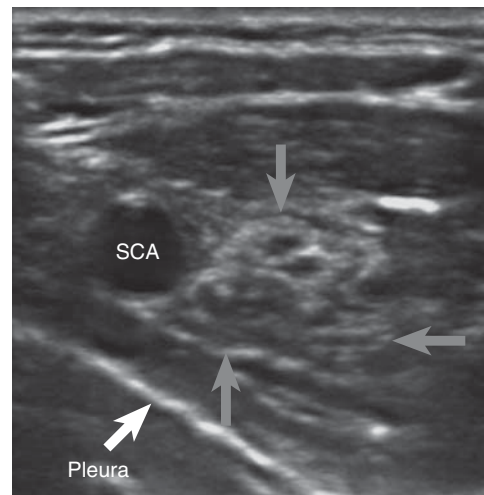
Ultrasound scan of the brachial plexus at the infraclavicular level below the pectoralis major and minor muscles. The three cords are labelled by grey arrows. SCA, subclavian artery.
